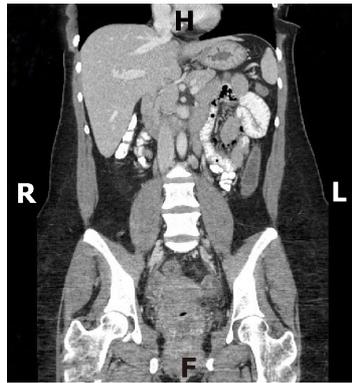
Computed tomography of abdomen with oral and intravenous contrast (coronal view). The computed tomography revealing thickened descending colon and rectum consistent with colitis.
